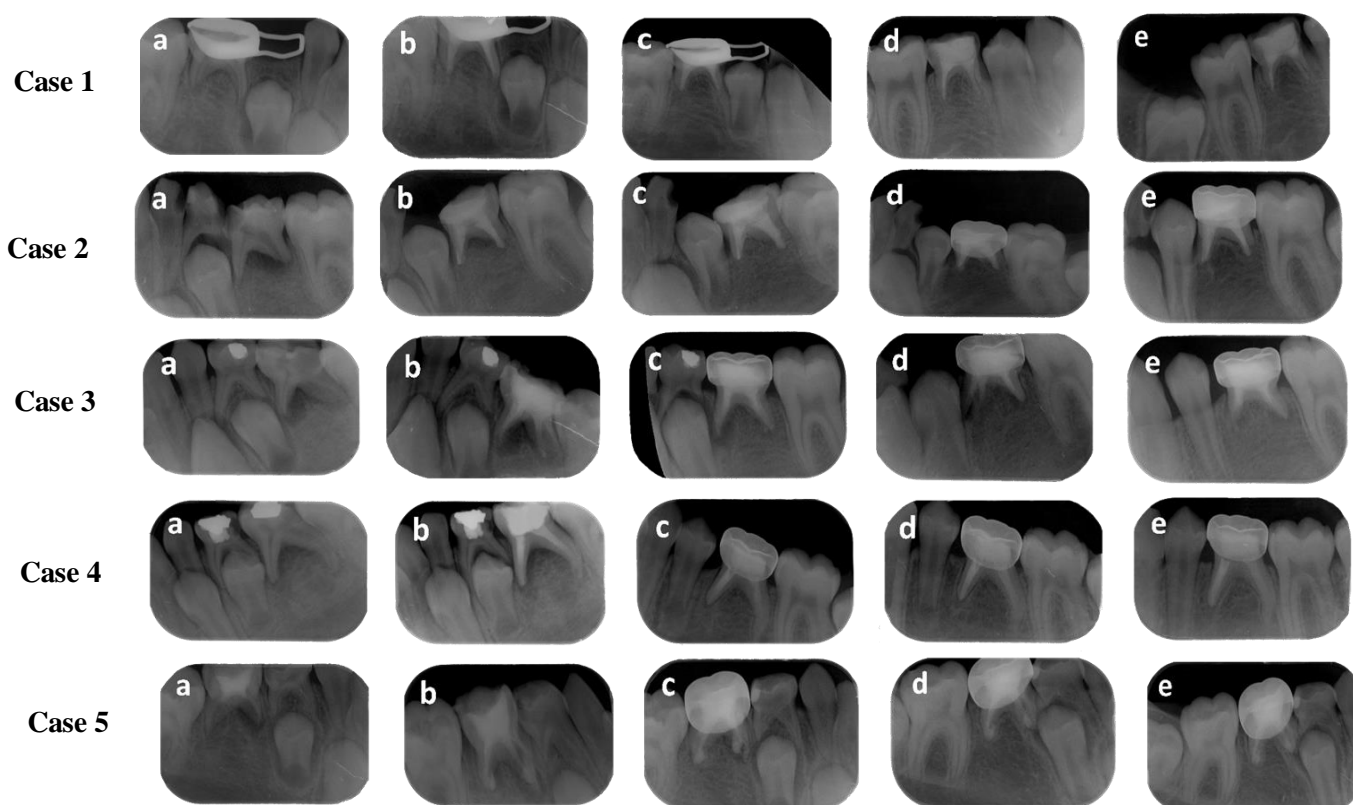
Root Canal Filling with NeoMTA a: Preoperative radiograph of the tooth. b: 6 months of follow-up. c: 12 months of follow-up. d: 18 months of follow-up. e: 24 months of follow-up
